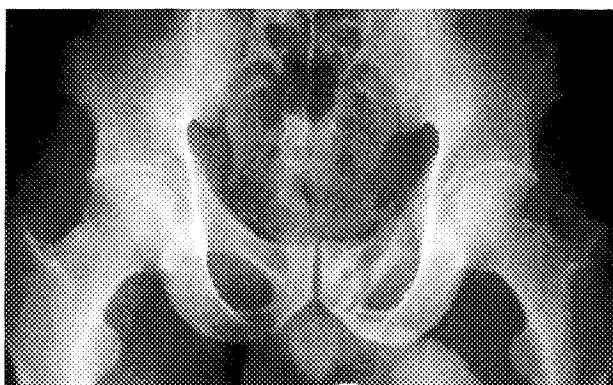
An anteroposterior roentgenogram of the pelvis 20 months after surgical removal of the lesion shows bony healing of the left superior pubic ramus
